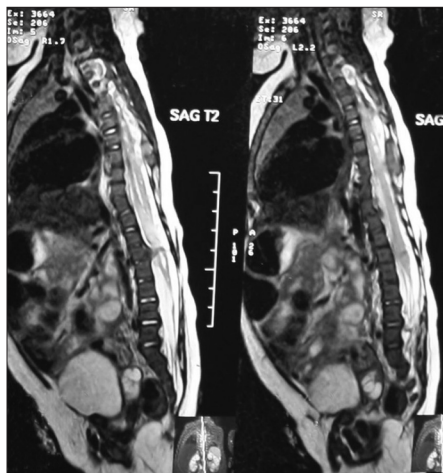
MRI spine (sagittal view) showing cord ending at L3
